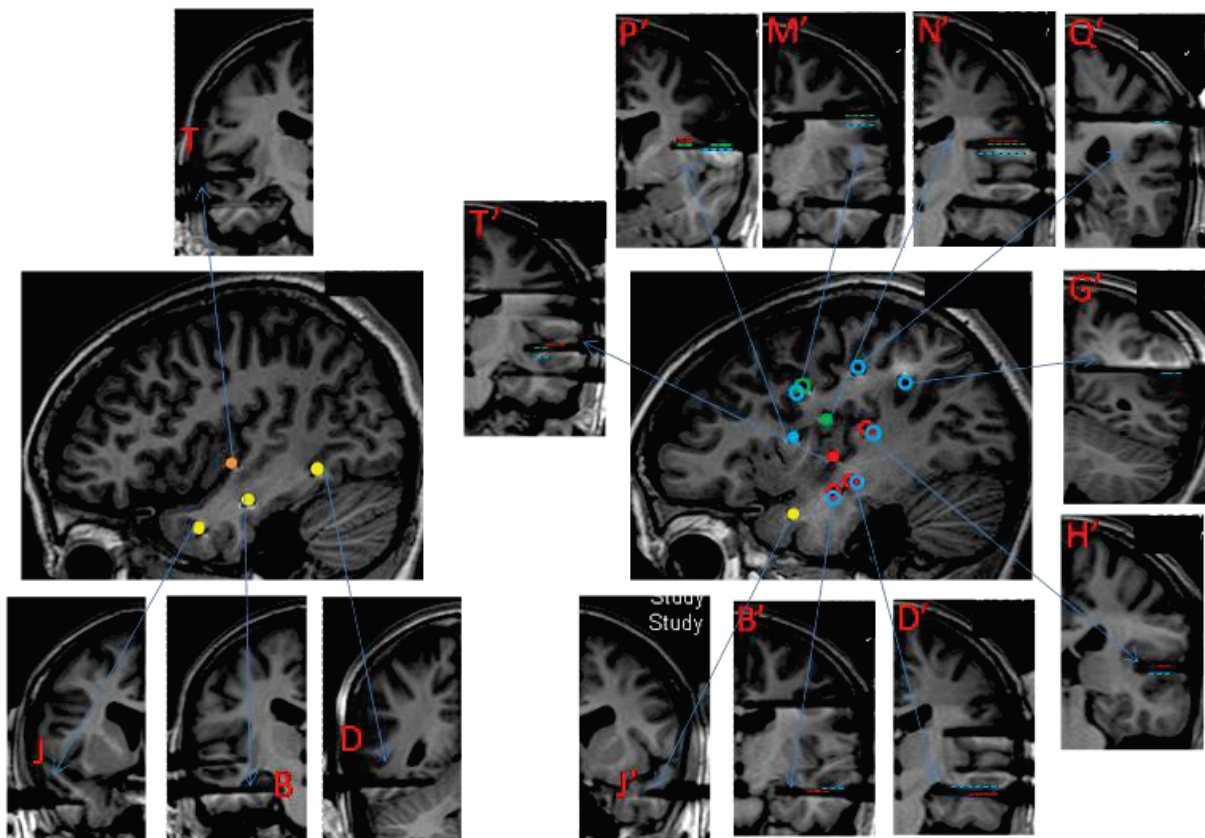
2: Patient 2 MRI with electrodes in place (Left and Right hemispheres). Central sagittal image: each insular electrode is represented by a unique colored solid circle; non-insular electrodes are represented by empty circles with the color of each of the insular electrode they are responding to. Yellow solid circles are for non responding electrodes. Peripheral coronal images: a cross-section of each electrode with its name and its responding contacts (responses are indicated by color coded dotted lines, representing the color of the corresponding stimulated insular electrode).
